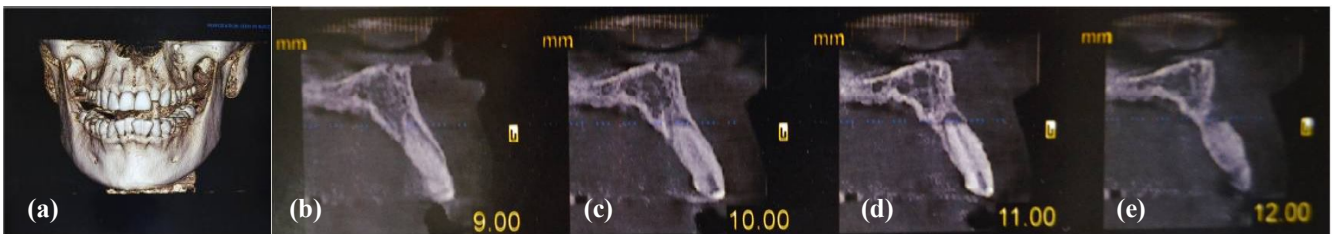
(a-e): Preoperative CBCT showing thin labial cortical bone)
